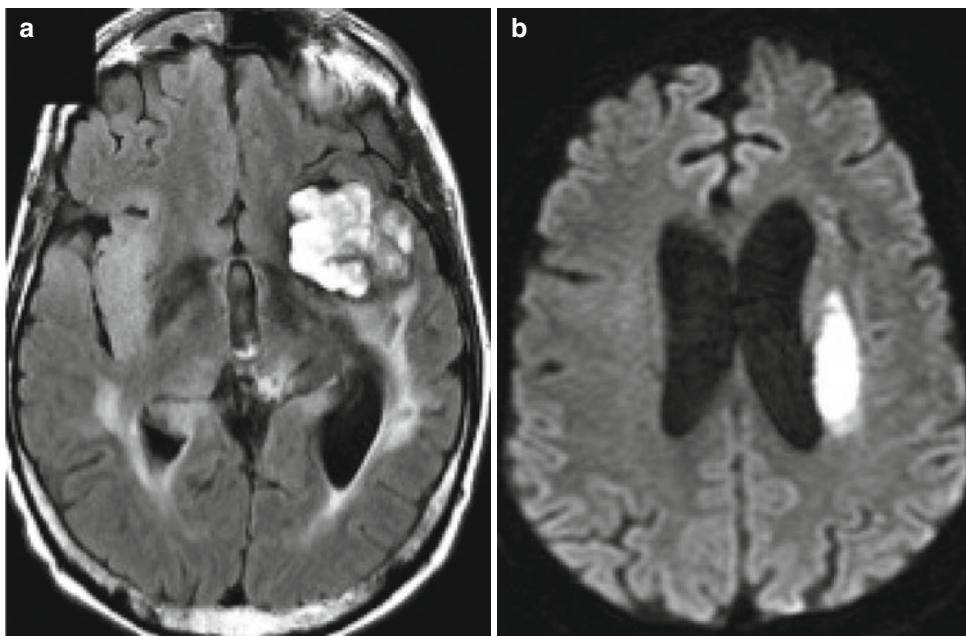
Parenchymal hematoma and secondary stroke in a patient with gliomatosis cerebri who received adjuvant temozolomide 3 days before. The possible link between temozolomide and stroke is unsettled; there are no vascular complications reported in the literature. (a) FLAIR images: left fronto-temporo-insular hemorrhagic lesion
